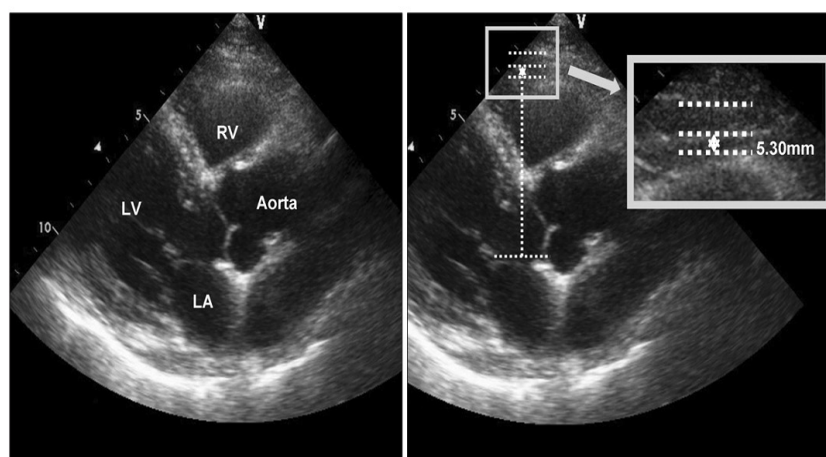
Example of measurement of epicardial fat thickness. Epicardial fat was identified as an echo-free space in the pericardial layers on the twodimensional echocardiography and its thickness was measured perpendicularly on the free wall of the right ventricle at end-diastole.
